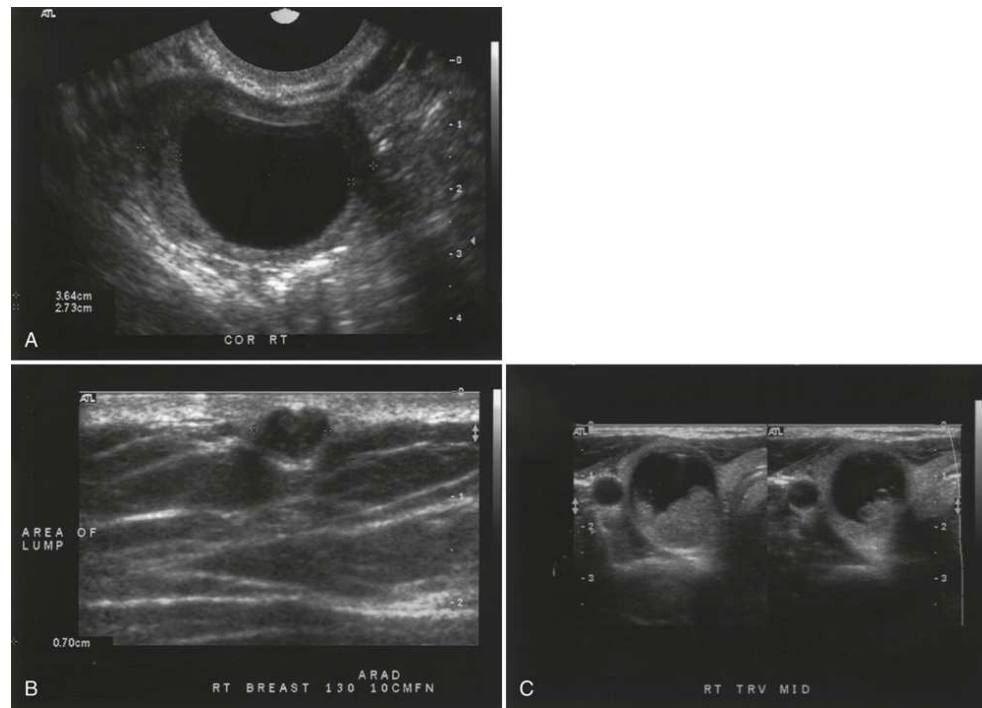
(A) Endovaginal sonogram of anechoic ovarian cyst. (B) Echogenic mass is measured in upper inner quadrant of right breast. (C) Transverse sonogram of complex thyroid mass. Courtesy Paul Aks, BS, RDMS, RVT.
